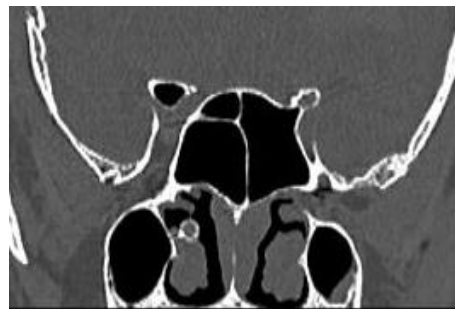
Oblique coronal CT scan showing Onodi cell and type 4 optic nerve on right side. Right ACP is showing pneumatization from Onodi cell. Type 2 optic nerve is seen on left side.
